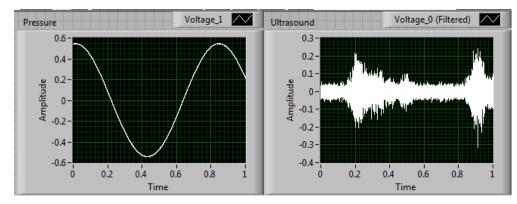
Plots of the collected sine wave (left) and ultrasound signal (right) showing the subjects pulse.
